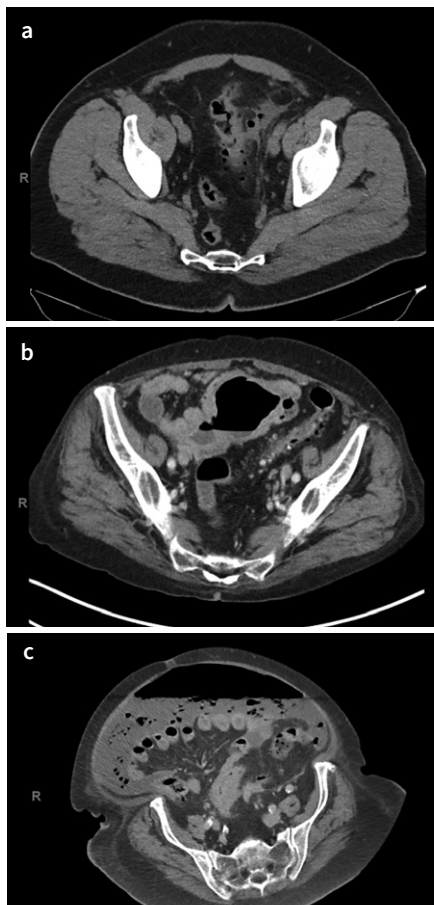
Abdominal CT scans of diverticulitis. a | Acute diverticulitis with pericolic extraluminal air. b | Diverticulitis with abscess formation (Hinchey II). c | Perforated diverticulitis with faecal peritonitis (Hinchey IV).
